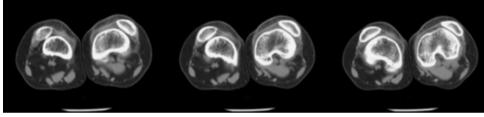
Patella of a patient lying outside of the femoral trochlear groove at three different levels on a CT scan. The articular side of the patella is flat, and the trochlear groove is dysplastic
